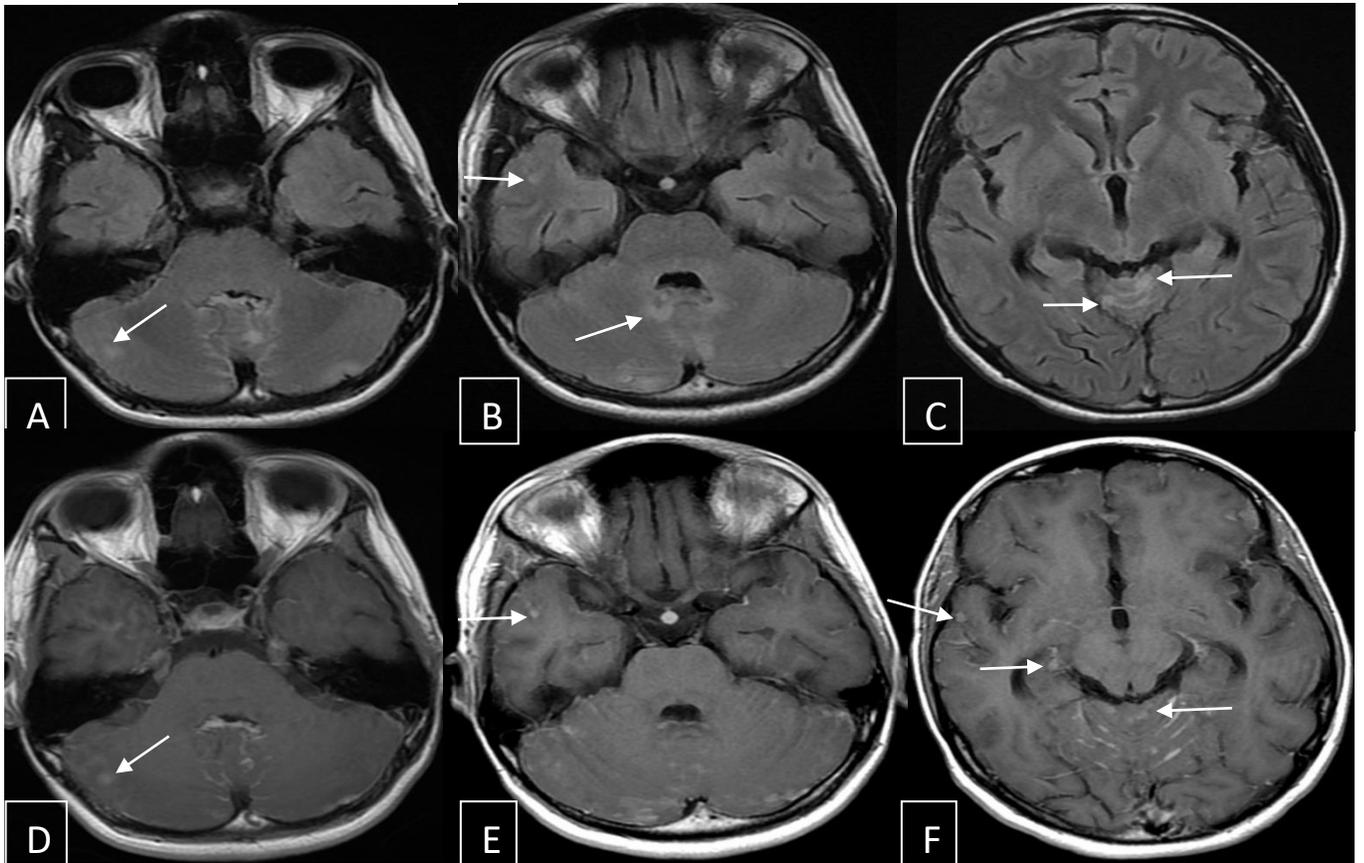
Brain MRI in FLAIR weighted axial views (A,B,C) and gadolinium-enhanced T1-weighted axial views (D,E,F) : Intracerebral hyperintense flair weighted nodular lesions, enhanced after gadolinium injection.
